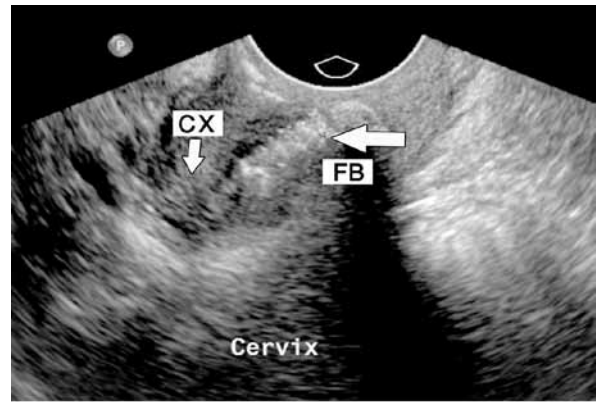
Pelvic ultrasound image showing the cervix (cx) with an echogenic lesion in the mid-cervical region. The echogenic lesion represents the neglected foreign body (FB; large arrow).
